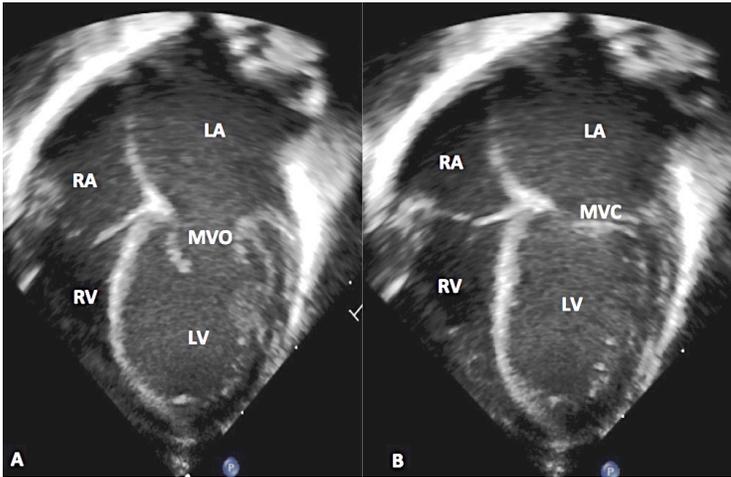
Echocardiographic frames from an apical four-chamber view demonstrating enlarged left atrium (LA) and left ventricle (LV). The mitral valve (MVO) is open in A and closed (MVC) in B. But, this enlarged LA and LV appearance is subjective. RA, right atrium; RV, right ventricle.
